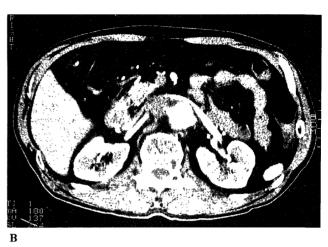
Abdominal aortic aneurysm involving the renal artery. A-C Contrast-enhanced CT shows an abdominal aneurysm which arises at the level of the origin of the right renal artery but it is difficult to determine exact relationship between the aneurysm and the renal artery solely on axial images.
